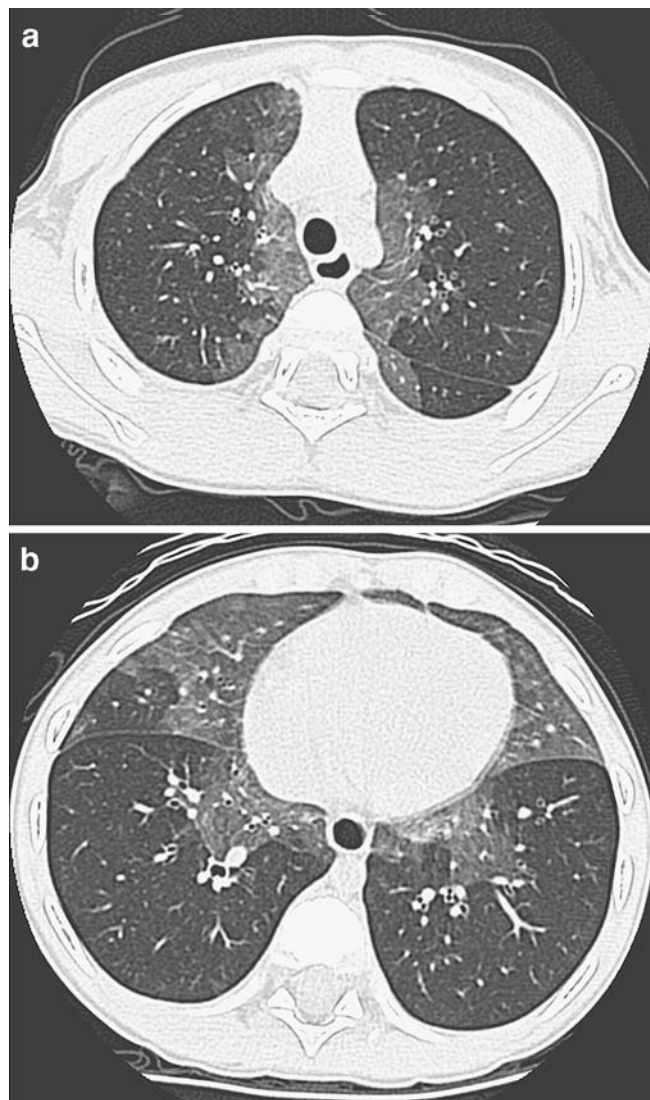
High-resolution CT images
